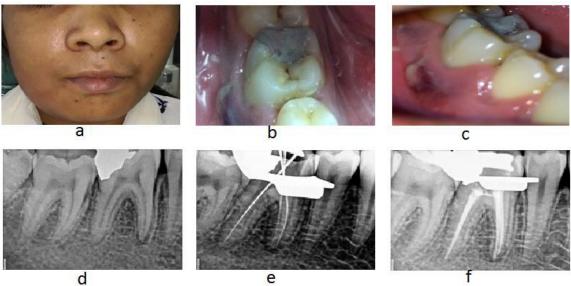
a-Extraoral swelling seen on the right side of face; 4.b- intraorally amalgam restoration seen on tooth 46; 4.c-periapical abscess seen on the buccal vestibule; 4.d-preoperative radiograph; 4.e- working length radiograph; 4.f-obturation radiograph.
